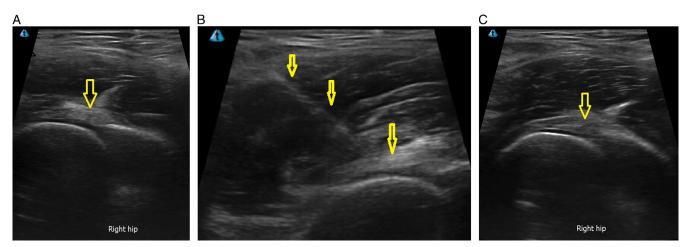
A, Musculoskeletal ultrasound of the hip-labral tear (open arrow). B, Ultrasound-guided needle guidance for PRP needle (open arrow). C, Musculoskeletal ultrasound of the hip status post-PRP resolution of tear (open arrow).
